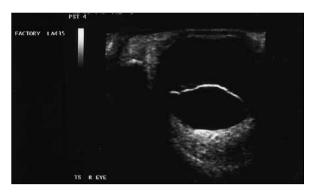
B-mode sonogram of the right eye (transverse section), using a 12-MHz linear transducer
